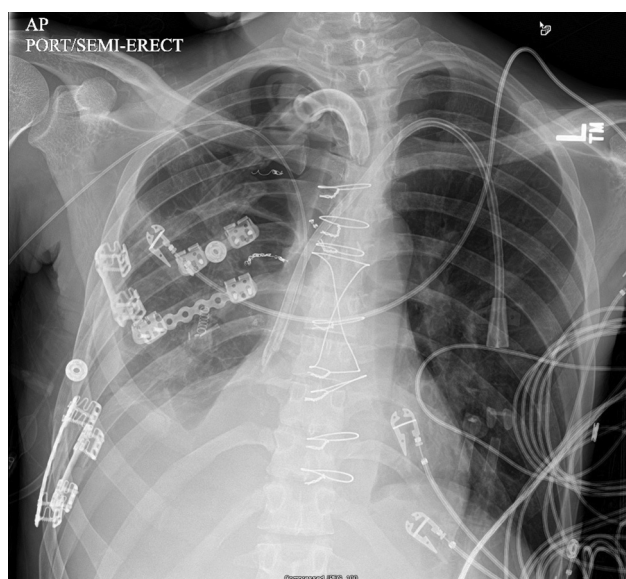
Anteroposterior (AP) postoperative chest roentgenogram showing rib fractures after fixation.
